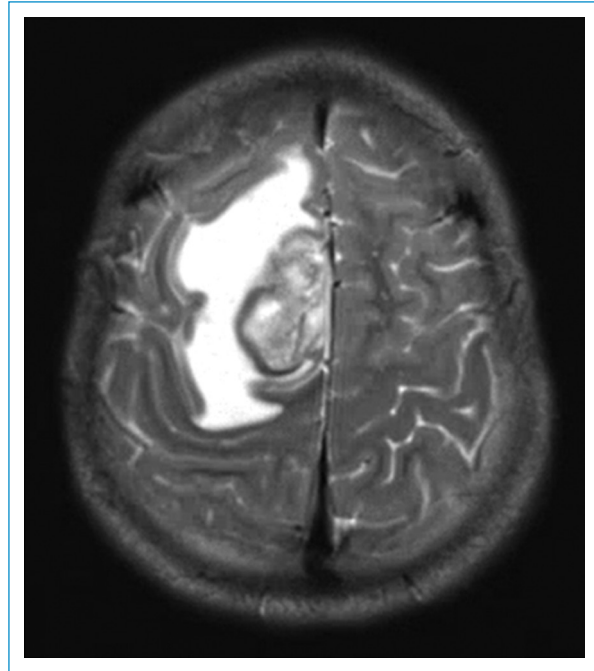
MRI, transverse plane.
